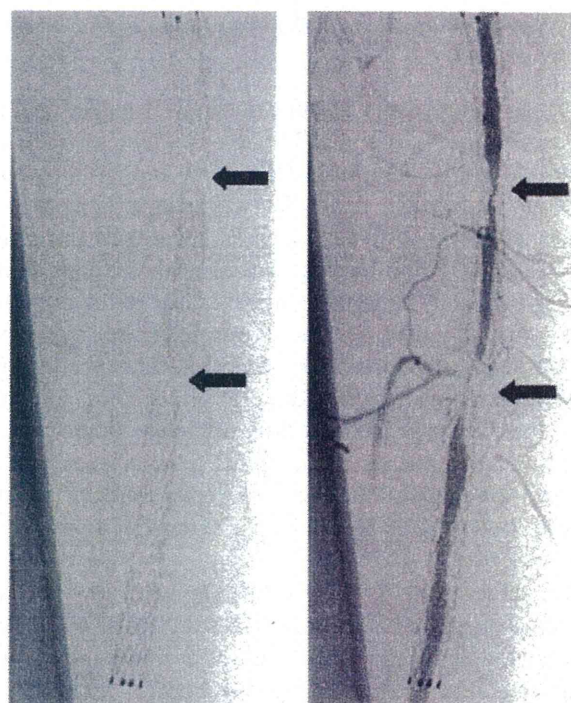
Early-stage fractures of self-expanding Ti–Ni femoral stents in service observed by x-ray examination [10].
